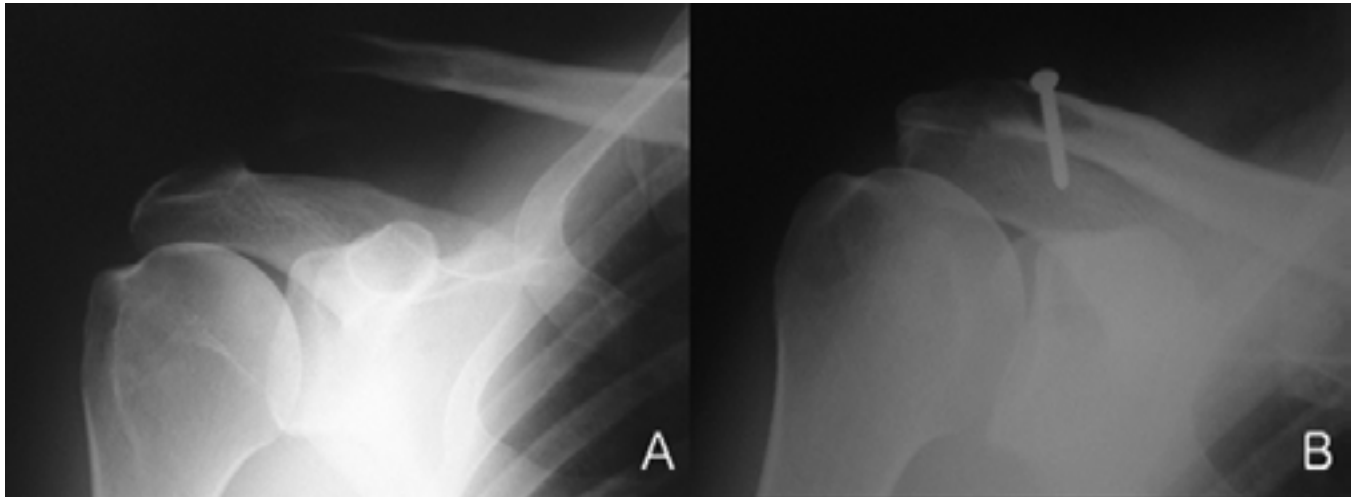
The preoperative (A) and postoperative (B) radiographs of the patient (case number 1).
